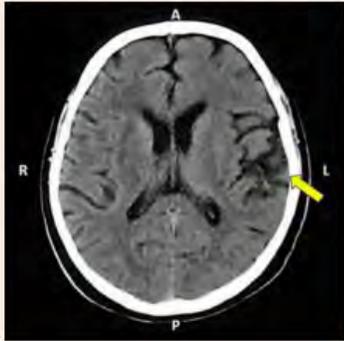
CT Scan at 10 months ago showed infarct of left temporoparietal lobe
